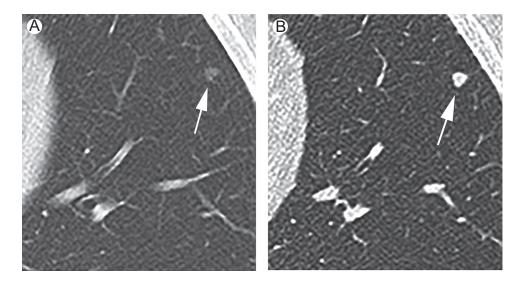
Thin CT sections facilitate accurate evaluation of nodule size and density. Noncontrast 5 mm axial chest CT image reconstructed with a sharp high-frequency algorithm and viewed under lung window settings (A) shows a nodule (arrow) in the left upper lobe that appears ground-glass in attenuation. Thin 1 mm axial image (B) reveals that the nodule (arrow) is actually solid in density. The margins are better seen on thin sections, enabling easier measurement.
